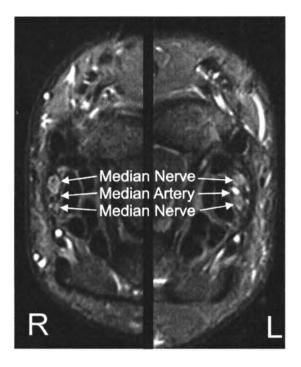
MR image of bilateral persistent median artery.
